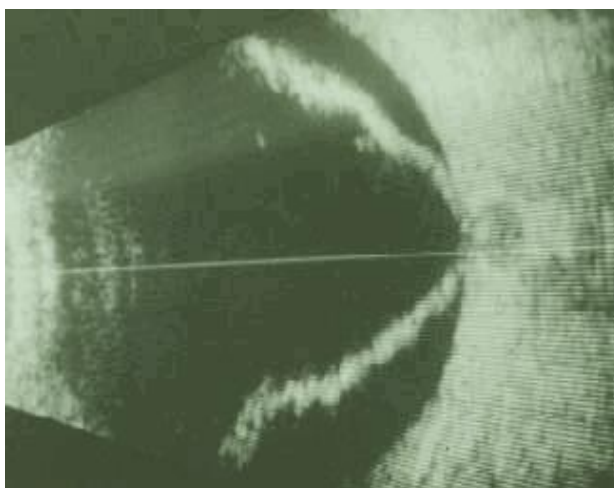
Ultrasound image of the retinal detachment, retinal layers being thick and immobile under pressure.
